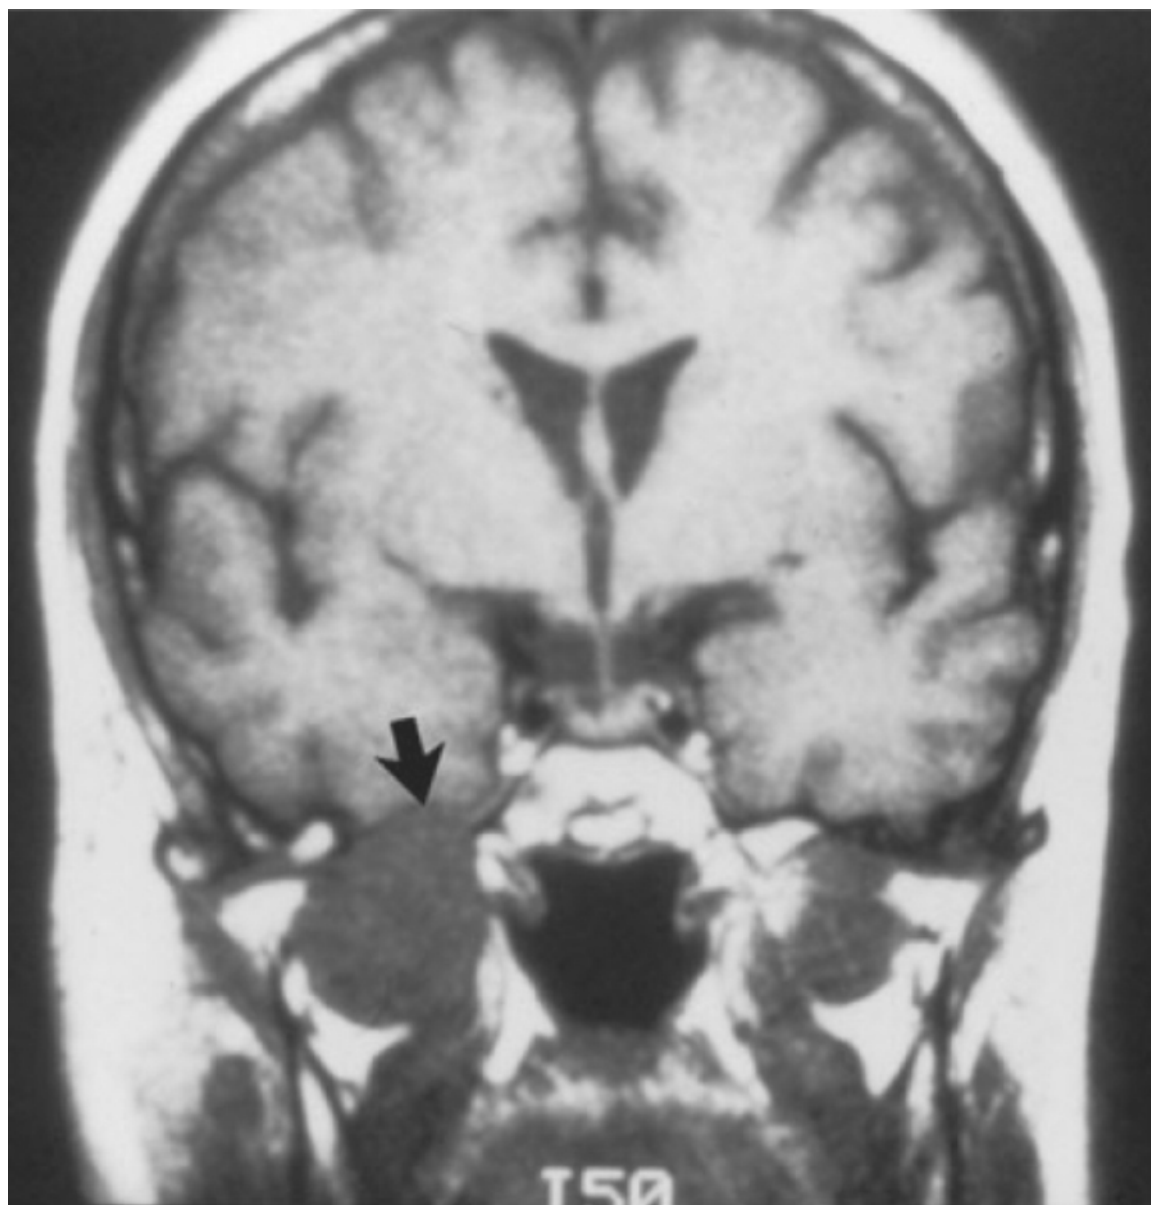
Magnetic resonance image demonstrating a neurilemmoma arising from the mandibular division of the trigeminal nerve (*arrow*). Although there is intracranial extension of the tumor, it is extracranial. Tumors in this location may reach a large size before they are visible or palpable on physical examination. Such tumors may cause facial numbness, pain, or difficulty with mastication.
